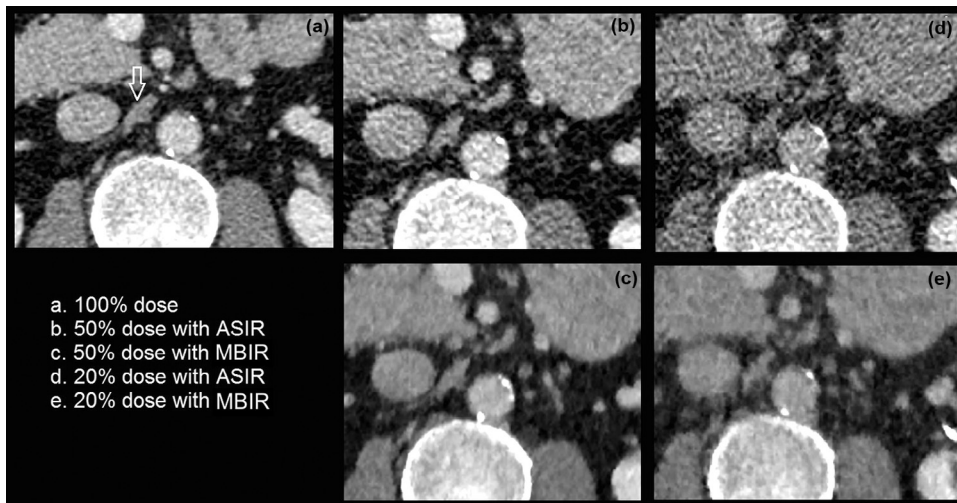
Side-by-side comparison of a retroperitoneal lymphadenopathy, detected on the 100% dose CT image (a, arrow) and the two iterative reconstruction algorithms and dose levels (b–e). Although the lesion can be detected on each image, delineation is best on the 100% dose (a) and 50% dose (c) MBIR images. Image noise definitely hampers the contour sharpness on both reduced-dose ASIR images (b,d) and on the 20% dose MBIR image (e). ASIR, adaptive statistical iterative reconstruction; MBIR, model-based iterative reconstruction.
